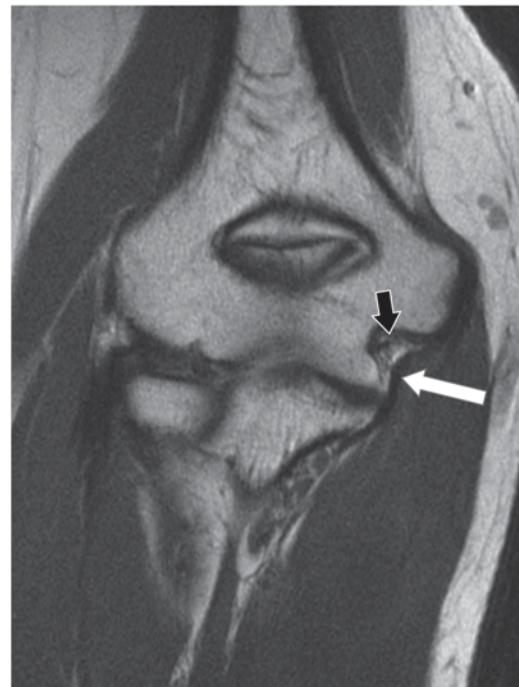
Coronal intermediate echo time FSE MR image of a normal thin, vertically oriented and hypointense UCL (white arrow). Note the normal infolding of synovium and fat deep to the ligament (black arrow)
